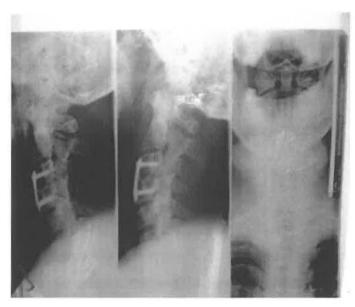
X-Ray of cervical region from segital (Lt. and Rt. view) and anterior view.
